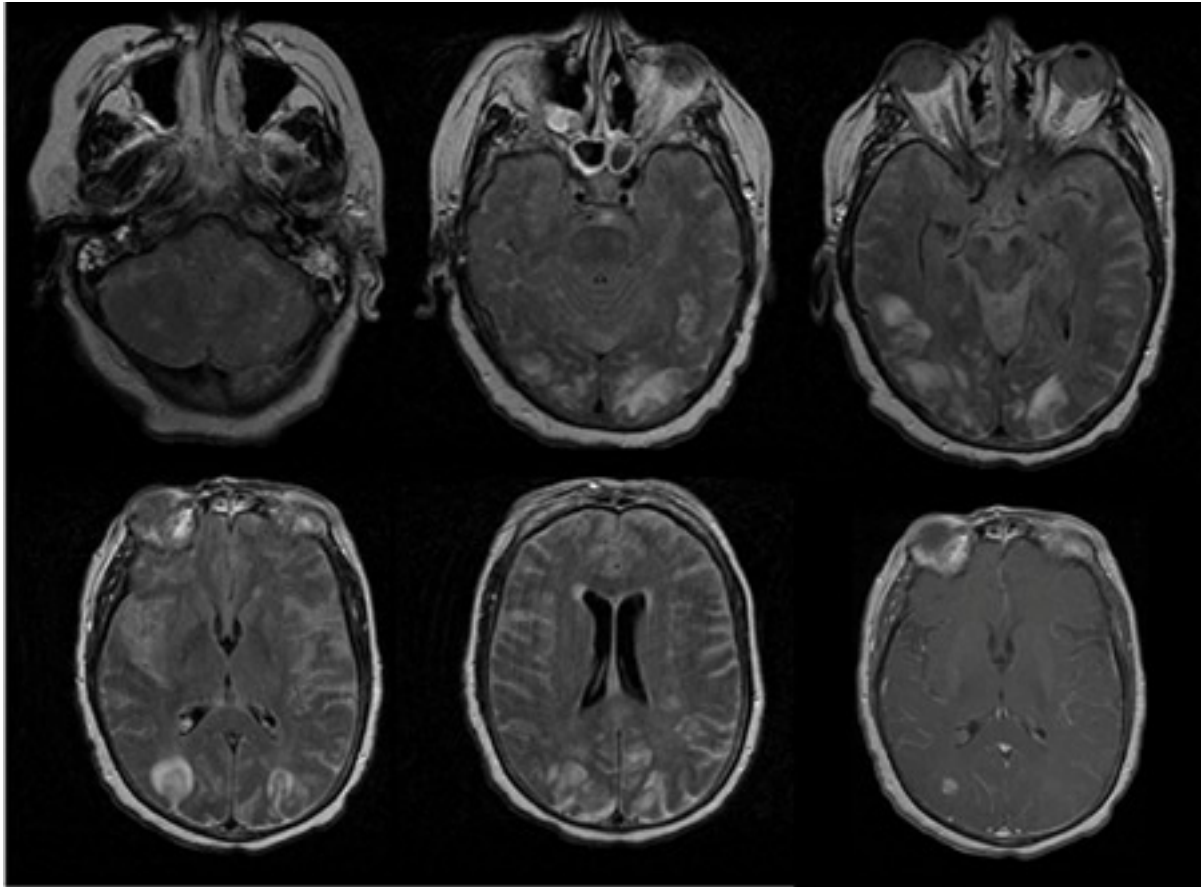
The first 5 images are FLAIR images of patient with varicella zoster virus meningoencephalitis showing white and gray matter hyperintensities. The last image is T1 image with contrast showing parenchymal and diffuse leptomeningeal enhancement
